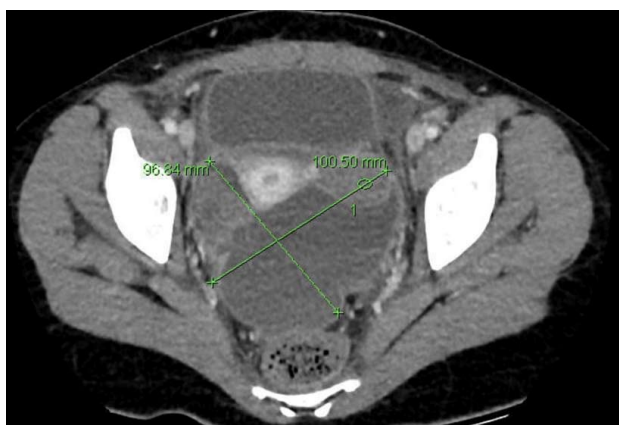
Pelvic collection - axial view. The computerised tomography (CT) scan on postoperative day 4 shows a large pelvic collection with dimensions of 10.1 cm × 9.6 cm. This CT view is the axial view. The collection shows different segments displaying different densities.
